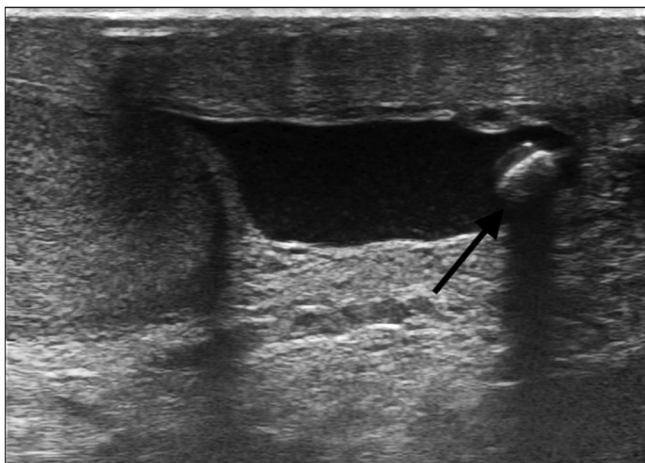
Greyscale ultrasound image of the left scrotal sac
